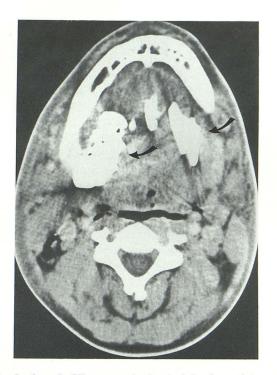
Case 3: CT scan at the level of the floor of the mouth demonstrates the air from the tracheotomy procedure that has dissected along fascial planes into the retropharyngeal and carotid spaces. There is no soft-tissue edema associated with the air tracking into these spaces. However, there is edema of the subcutaneous tissues and fat planes around the submandibular glands, secondary to the cellulitis. The *curved arrows* denote drains from the prior surgical procedure.
